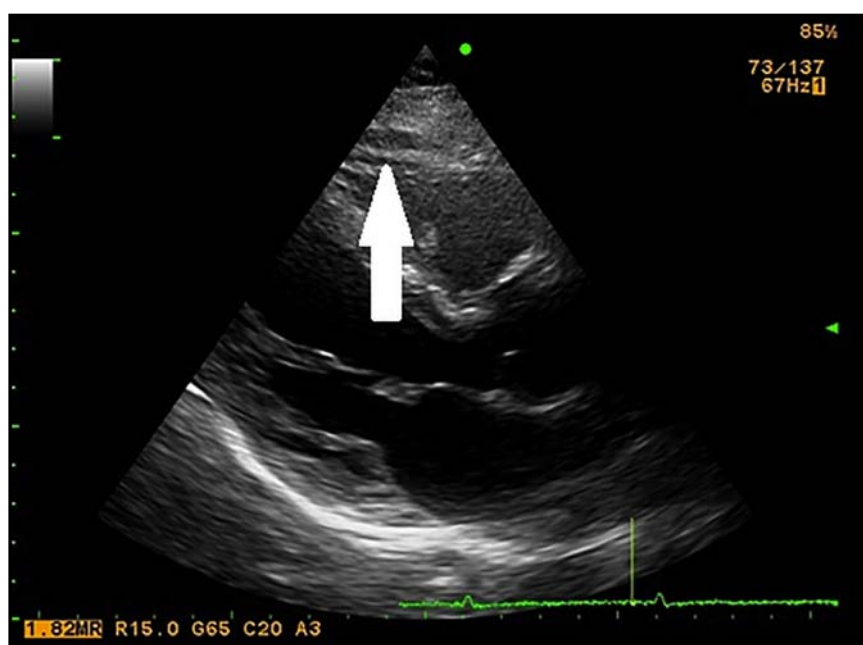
Epicardial fat – 2-dimensional echocardiography. Arrow depicting epicardial fat
